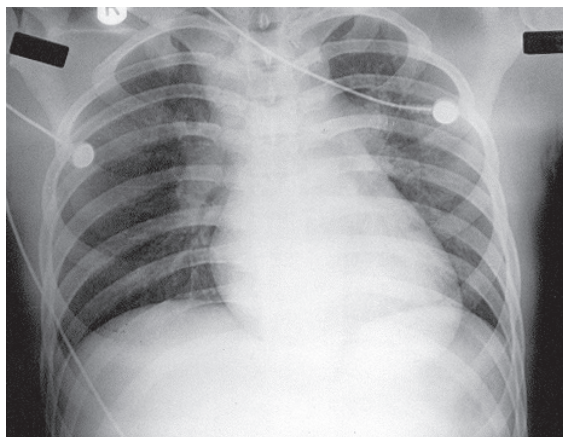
Chest radiograph shows a widened mediastinum and globular cardiomegaly on presentation.
